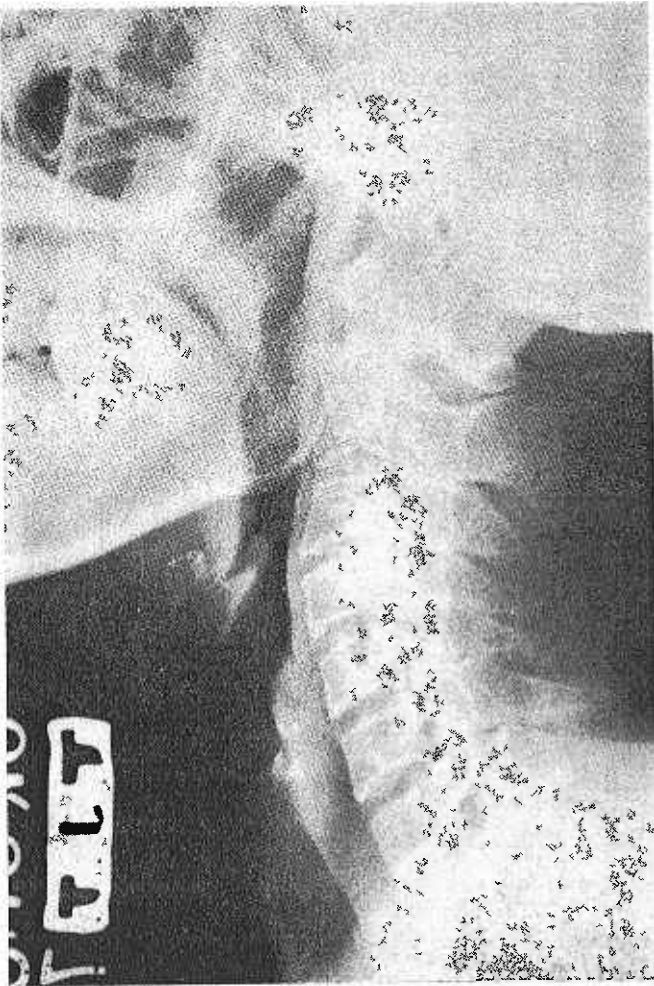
L. M. G., female, 55. Lateral radiograph showing a "typical" or "ideal-looking" nasopharynx. The roof is of medium thickness and slightly concave. The "Bend" is slightly over 90 degrees. The "Bay" is medium. "FM vertical" is of medium length and slightly convex inferiorly. The tip of uvula is at the level of the middle of the body of the axis. The posterior walls of both maxillary sinuses, the posterior part of inferior turbinate, pterygoid bones and Eustachian fossa are well seen. The upper chamber of nasopharynx is funnel-shaped. This lateral radiograph of the neck is taken with the cassette against the lateral shoulder. Note the wide coverage of parts including the entire cervical spine, pharynx and larynx. This and the succeeding reproductions are lateral radiographs of the neck made on Chinese patients.
